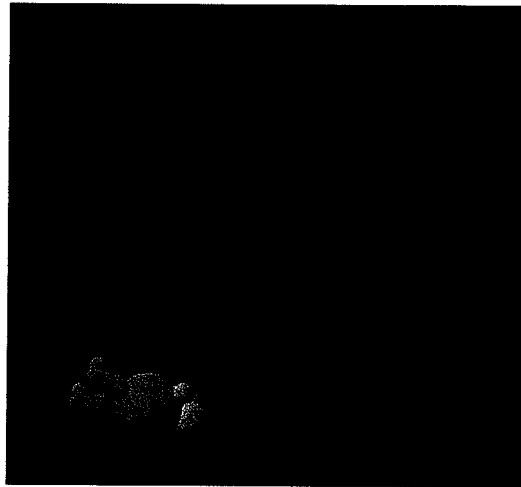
Three-dimensional view of the CT-defined prostate (blue) and MRI-defined prostate (pink). CT-defined rectum is shown as wire frame blue.
